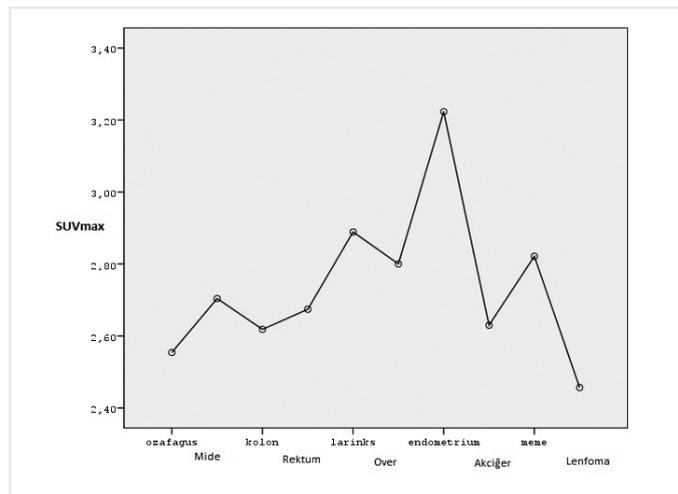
Mean SUV_{max} measurements of ROIs plotted on the right lobe of liver according to diagnosis
